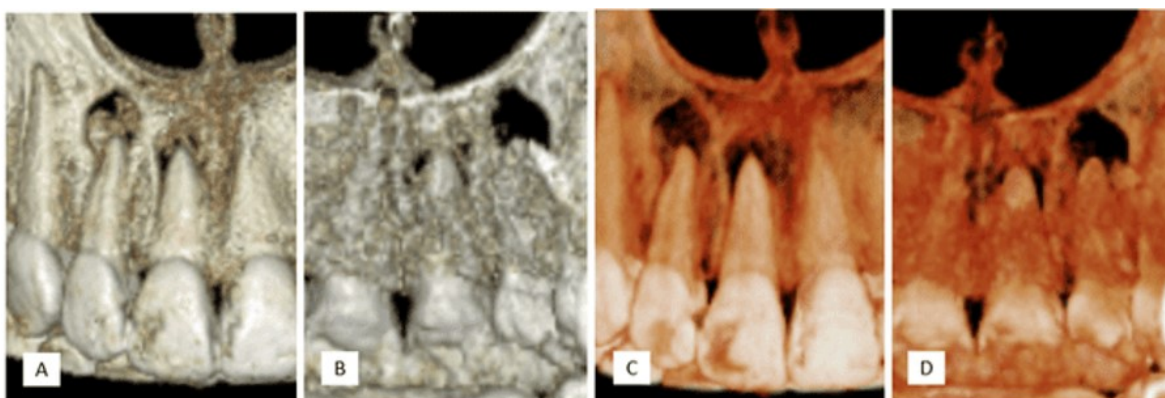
Reconstructed 3D images in CBCT radiograph of the patient showed that there are two seemingly-separated periapical rarefying osteitis lesions in apical third of 11 and 12; A) Bone labial view, B) Bone palatal view, C) Tooth labial view, D) Tooth palatal view
